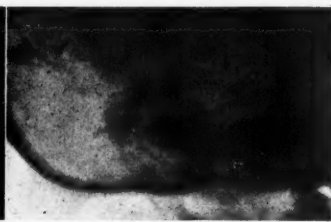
Roentgenogram of the temporal bone after the Stenvers method. Sarcoma of the middle ear. Of the pyramid only the compact labyrinthine nucleus with the bony labyrinth can be clearly distinguished. The pars mastoidea is entirely destroyed. Of the apex of the pyramid only slight traces can be seen.
